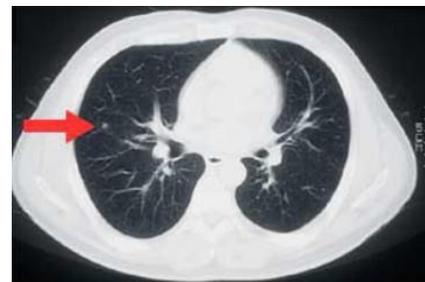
3D MRI scan slice containing Cancer
